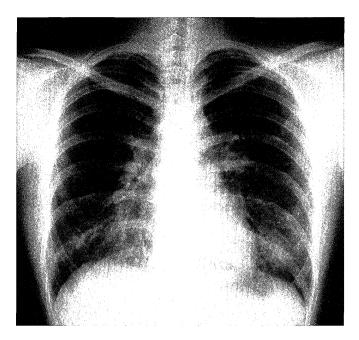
Chest roentgenogram performed on May 18, 2001 showing infiltrative shadow in bilateral lower lobes, suggesting lung metastases.
